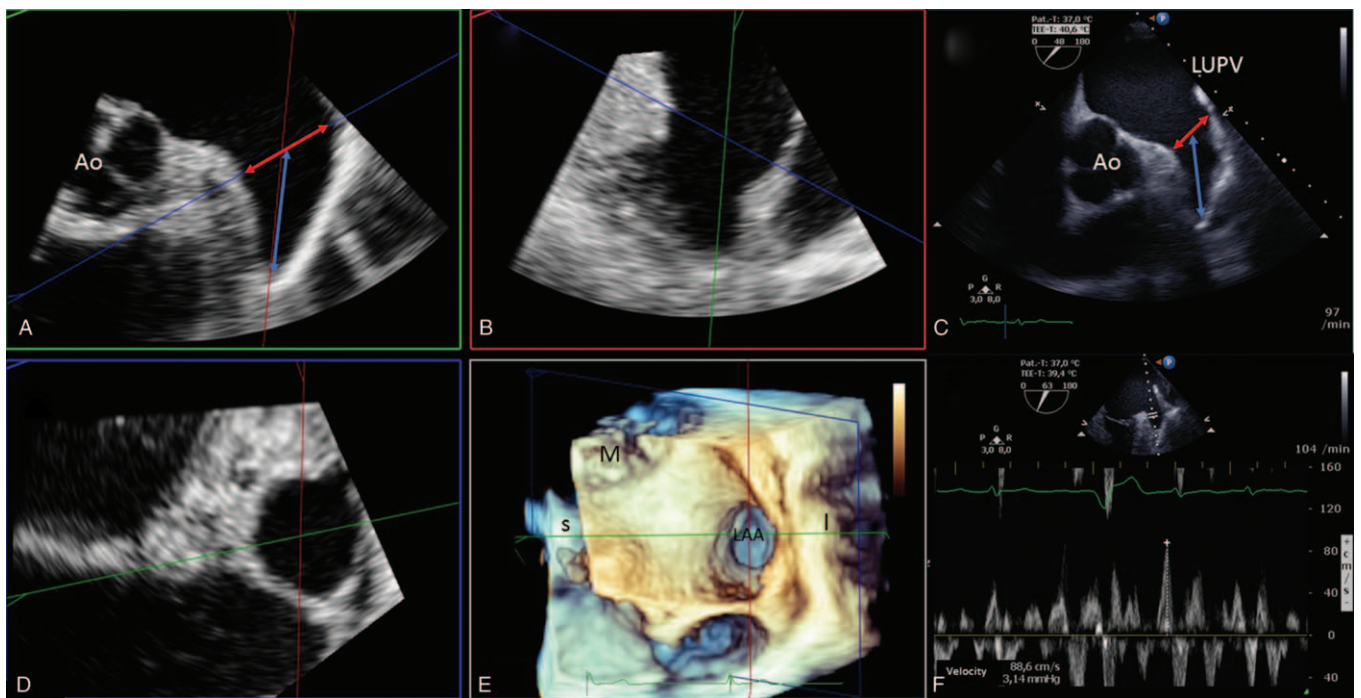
Assessment of LAA diameters and LAA velocity. LAA expansions were measured by determining orifice width and LAA depth. LAA orifice width (marked as red arrow) was estimated by measuring septo-lateral diameter in short axis view (SAX) as an approximated plane from the left coronary height (septal) to 1 to 2 cm below the highest point of the LUPV (left upper pulmonary vein)-limbus ("rim" / lateral); LAA depth (marked as blue arrow) was determined as distance from orifice plane to the deepest point of the LAA. If available, measurements were performed by multi-planar reconstruction of three-dimensional echo loops (Panels A, B, D: Panel A shows a reconstructed plane resembling SAX-view in left upper quadrant, Panel B another reconstructed longitudinal plane orthogonal on Panel A, Panel D the reconstructed "orifice" of the LAA). Panel C demonstrates measurements in "conventional" 2-dimensional TEE at about 45° resembling SAX-view. Panel E shows spatial relations in the LA in a 3-dimensional overview in "non-surgical" orientation. Panel F shows the determination of blood velocity in the LAA via PW-doppler in a patient with present atrial fibrillation (obviously shown by PW-curve demonstrating rapid and irregular LAA contractions). Ao = indicates aortic valve, l = lateral orientation, LAA = left atrial appendage, LUPV = left upper pulmonary vein, M = mitral valve, s = septal orientation.
